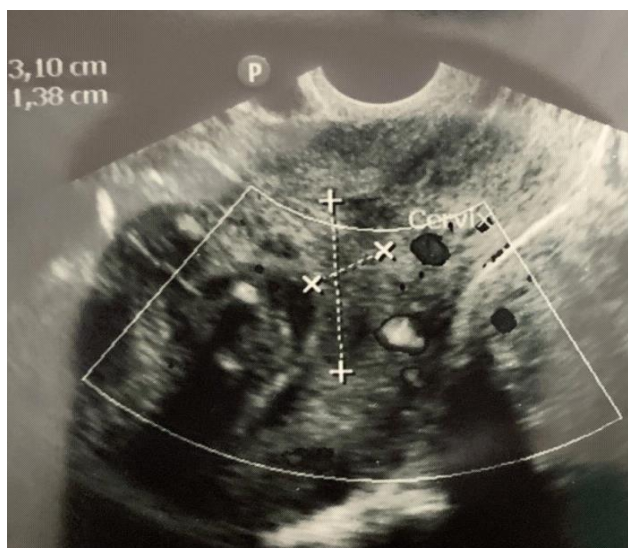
Ultrasonic picture presenting isoechoic area measuring 31×13 mm above the cervical orifice.
